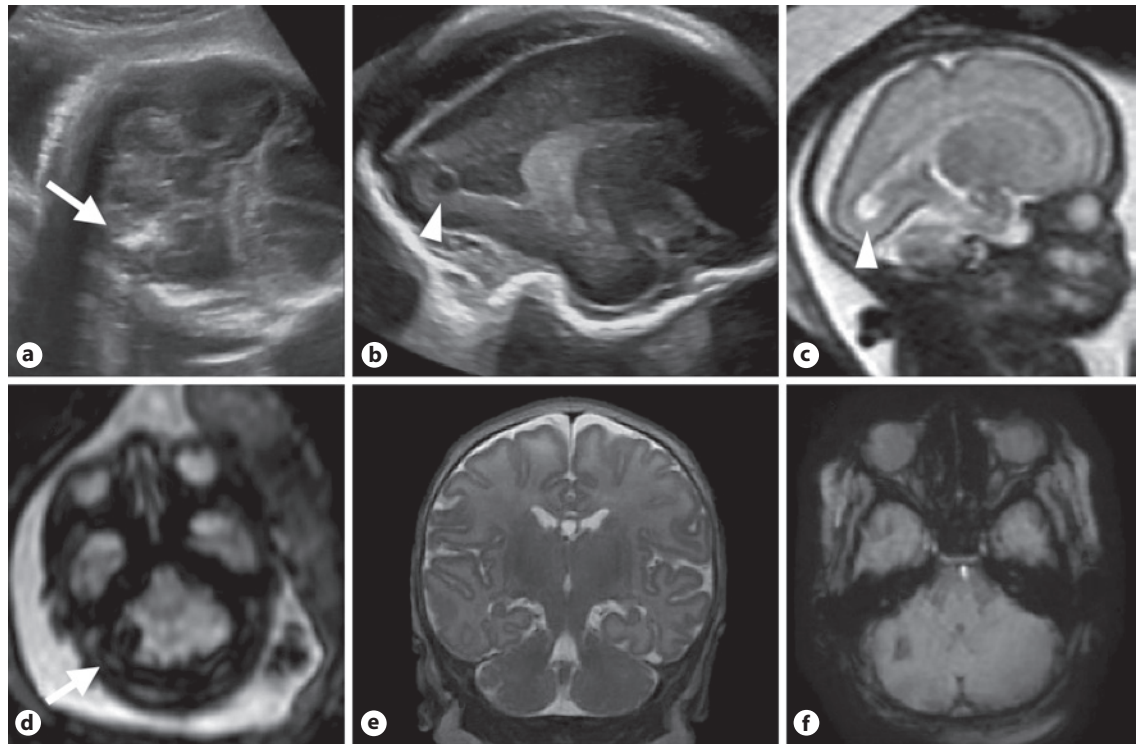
Case 7. Cerebellar hemorrhage, occipital pseudocyst, and normal vermis. The encephalic and cerebellar biometry values were below the 3rd percentile. a, b Ultrasound scans at 28 weeks of gestation. a Axial slice at the level of the cerebellum showing increased echogenicity (arrow) in the lateral part of the right cerebellar hemisphere, suggesting a hemorrhagic insult. b Parasagittal ultrasound view at the level of a lateral ventricle demonstrating a pseudocyst (arrowhead) facing the occipital horn. c, d MRI at 28 weeks of gestation. c T2-weighted parasagittal slice at the same level as in b; the occipital pseudocyst is well depicted (arrowhead).
